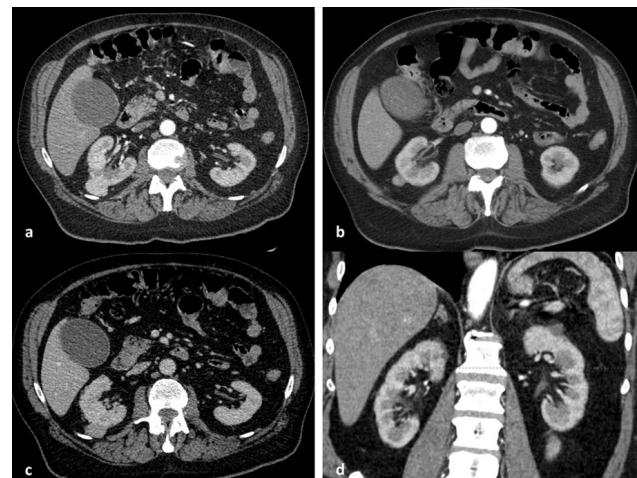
Axial (a and b) and coronal (d) arterial phase abdominal CT. Axial (c) portal phase abdominal CT.
